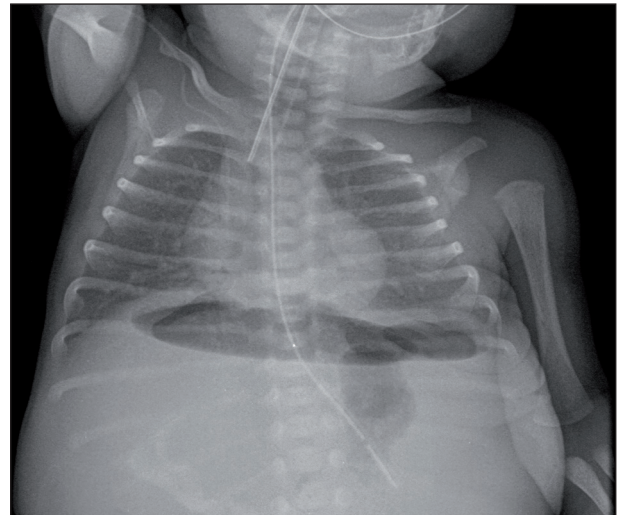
Abdominal X-ray on the 5th day of life revealing pneumoperitoneum.
